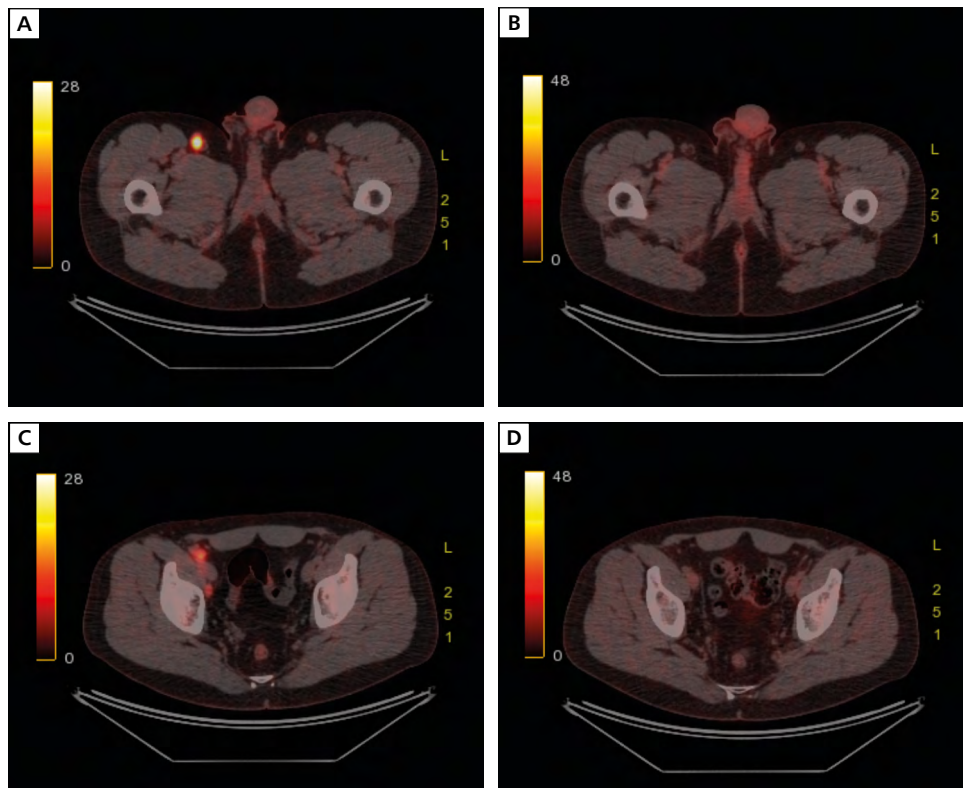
Positron emission tomography (PET-CT) evaluation of CIC-DUX4 sarcoma with metastatic inguinal (A, B) and iliac (C, D) lymph nodes before (A, C) and after (B, D) doxorubicin chemotherapy
